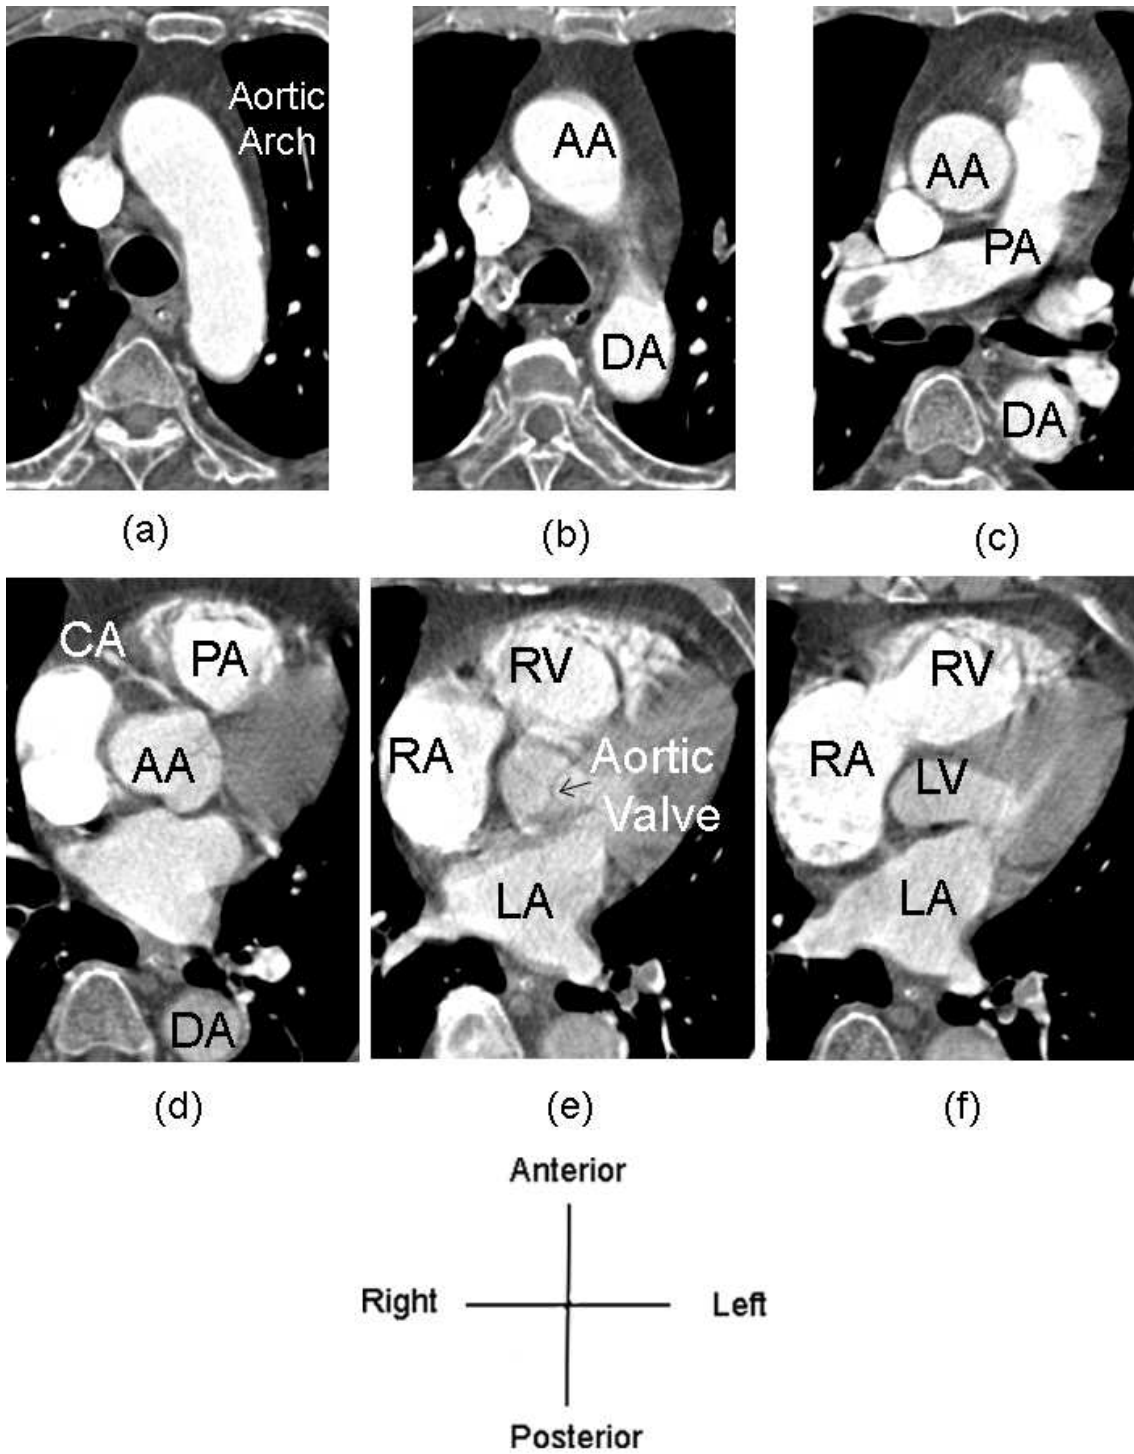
CT images of normal heart. (a)-(f): From top to bottom of the heart. AA: ascending aorta, DA: descending aorta, PA: pulmonary trunk, CA: coronary arteries, LA: left atrium, RA: right atrium, LV: left ventricle, and RV: right ventricle.
